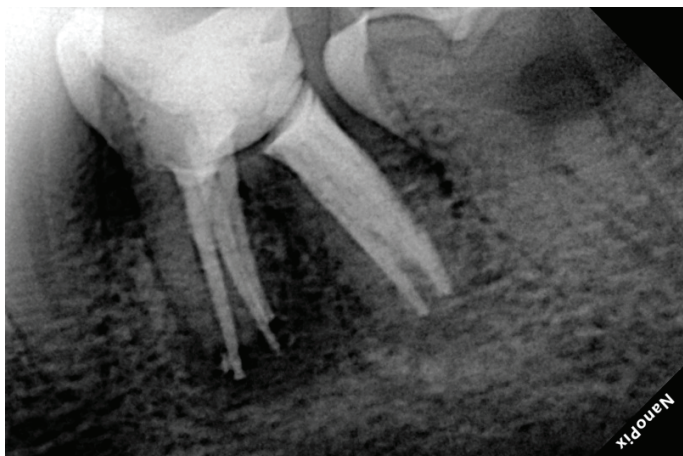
Postoperative radiograph of the first molar
